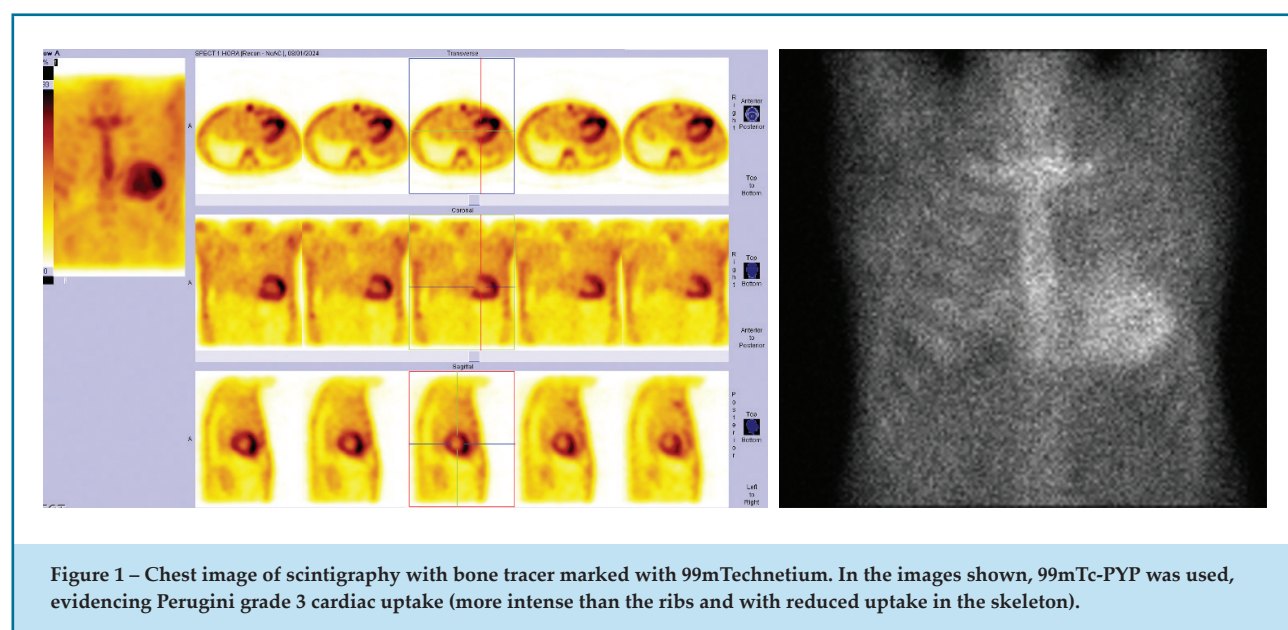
Chest image of scintigraphy with bone tracer marked with ^{99m}Tc . In the images shown, ^{99m}Tc -PYP was used, evidencing Perugini grade 3 cardiac uptake (more intense than the ribs and with reduced uptake in the skeleton).
